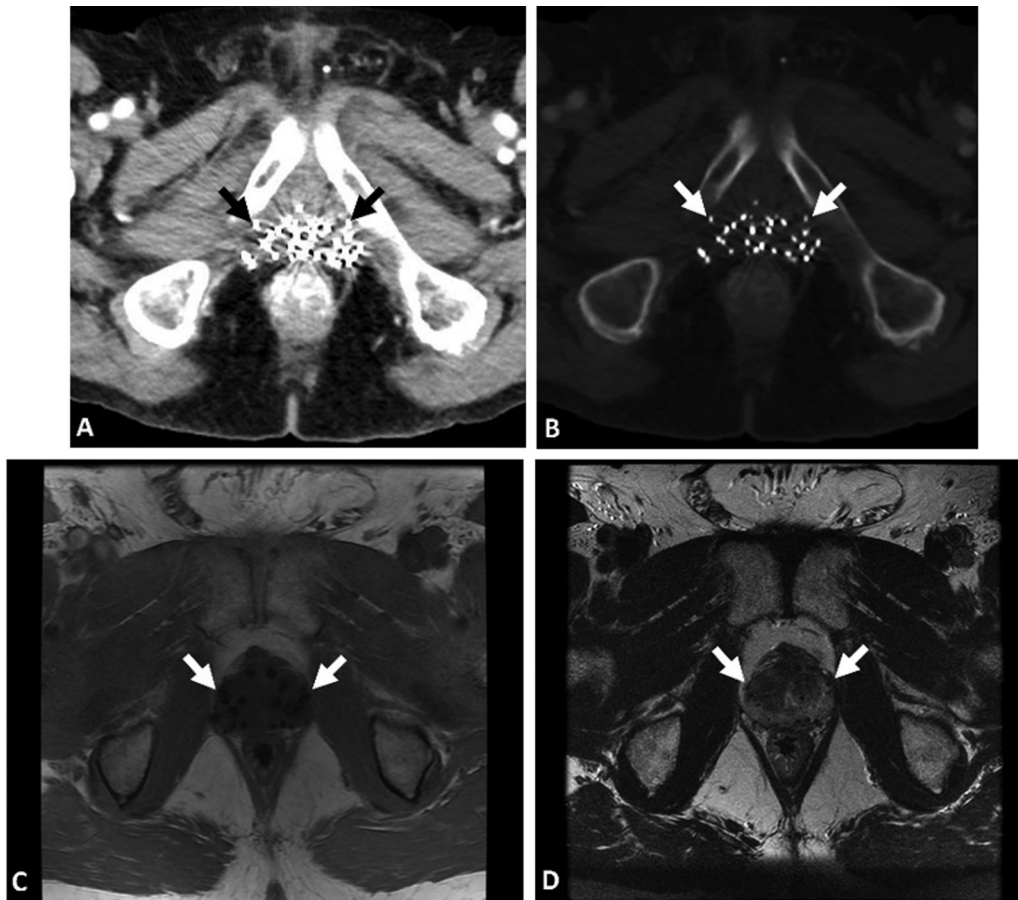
Brachytherapy seeds. Brachytherapy seeds (arrows) on (A) soft tissue and (B) bone windows of contrast-enhanced computed tomography (CT) appearing as metallic densities in the prostate gland causing streak artifacts due to proton starvation. Brachytherapy seeds in a different patient appearing as signal voids in the prostate gland on (C) T1-weighted and (D) T2-weighted images.
